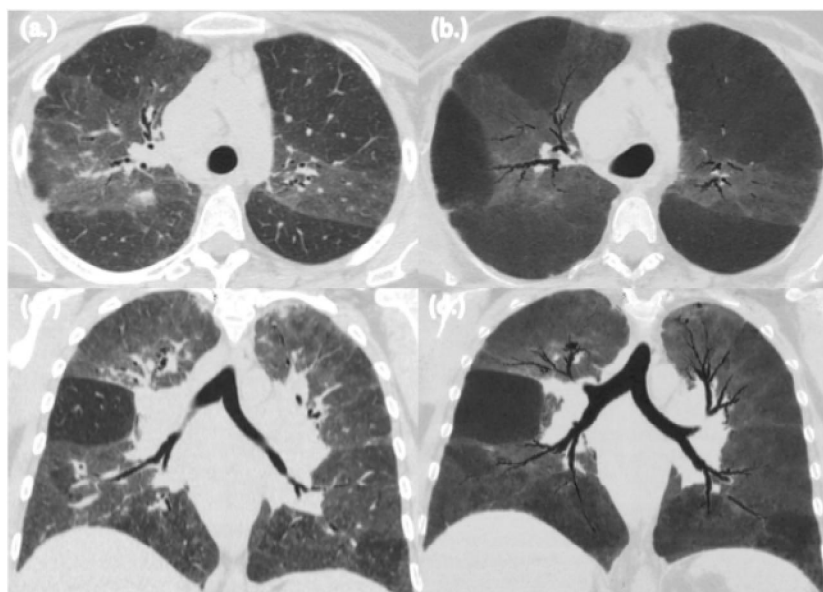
A 42 years old female patient (known sarcoidosis) is presented by dyspnea. Axial Section and coronal reconstruction of non-contrast CT chest scan (Case 9) (known sarcoidosis) shows (a, c) Volumetric HRCT shows bilateral apical Reticulonodular infiltrates, mild bronchial tree dilation with peribronchial thickening. The cystic changes are better visualized in the (b, d) MinIP images.
